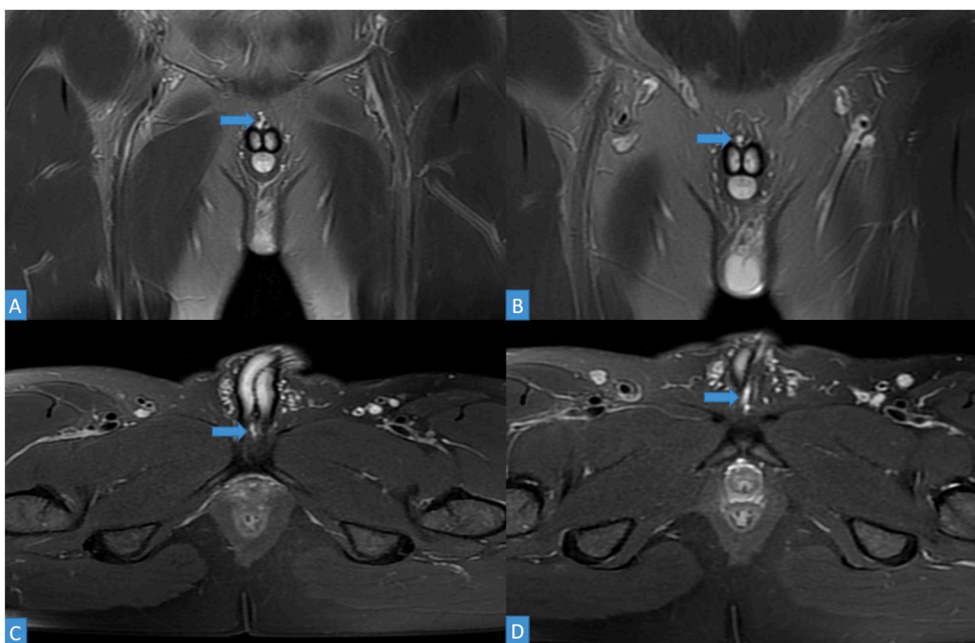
Follow-up MRI after one year shows linear increased in axial (A,B) and coronal (C,D) T2 PROPELLER images T2WI fluid signal in the central part of suspensory ligament fibers (arrow) without any sign of healing.
